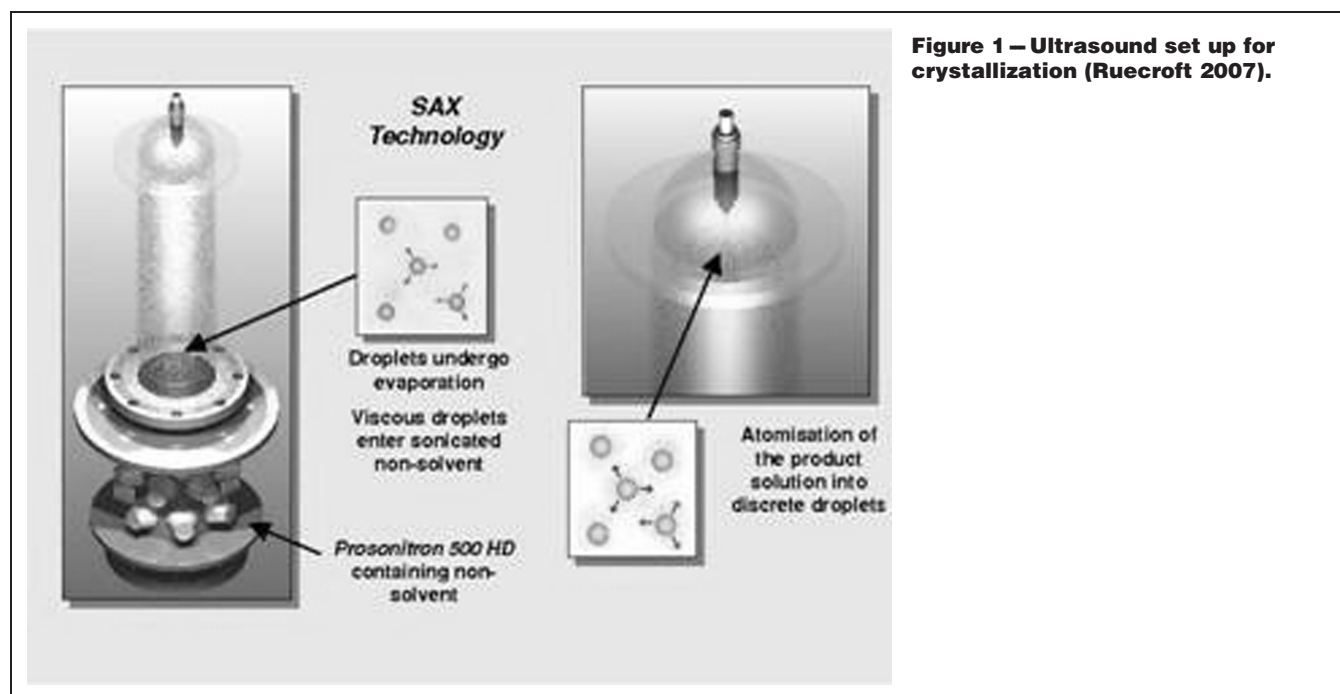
Ultrasound set up for crystallization (Ruecroft 2007).
